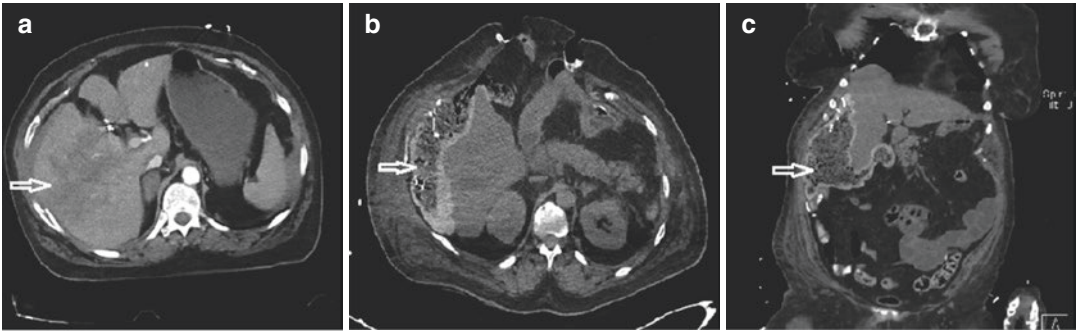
Abdominal CT images of the packing (b, c) technique (Arrows) we applied in a patient with grade 5 liver trauma (a)
